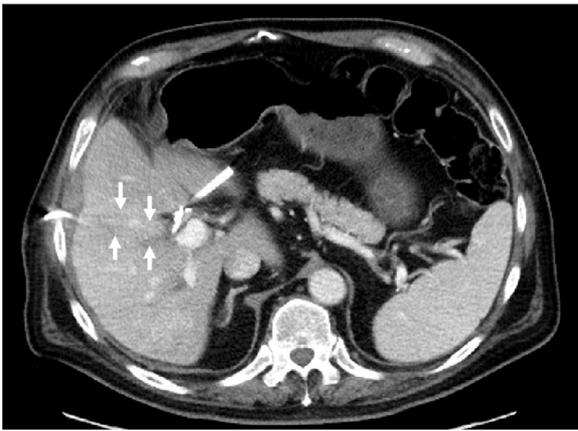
A 56-year-old man with a percutaneous biliary drain. Missed occlusion of a right portal vein branch on contrast-enhanced CT. Small white arrows denote the expected location of the vein. This diagnosis is made difficult by the absence of a structure (the vein) rather than the presence of an expansile clot.
